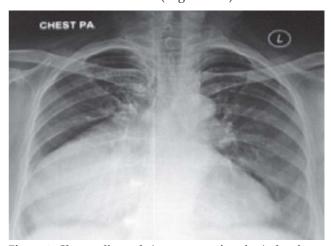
Chest radiograph (postero-anterior view) showing a right-sided para-cardiac opacity.
